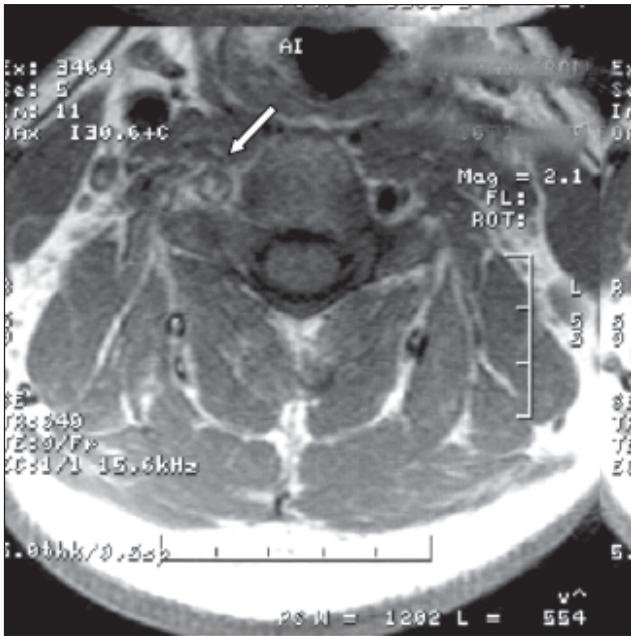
Cerebral MRI - T1 weighted image – the intramural haematoma at the level of the right PICA
